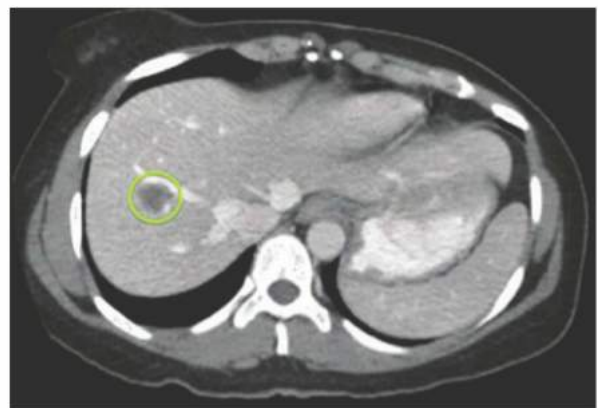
• CT image of liver, portal venous phase. Encircled is a metastatic colon lesion to the right liver.
